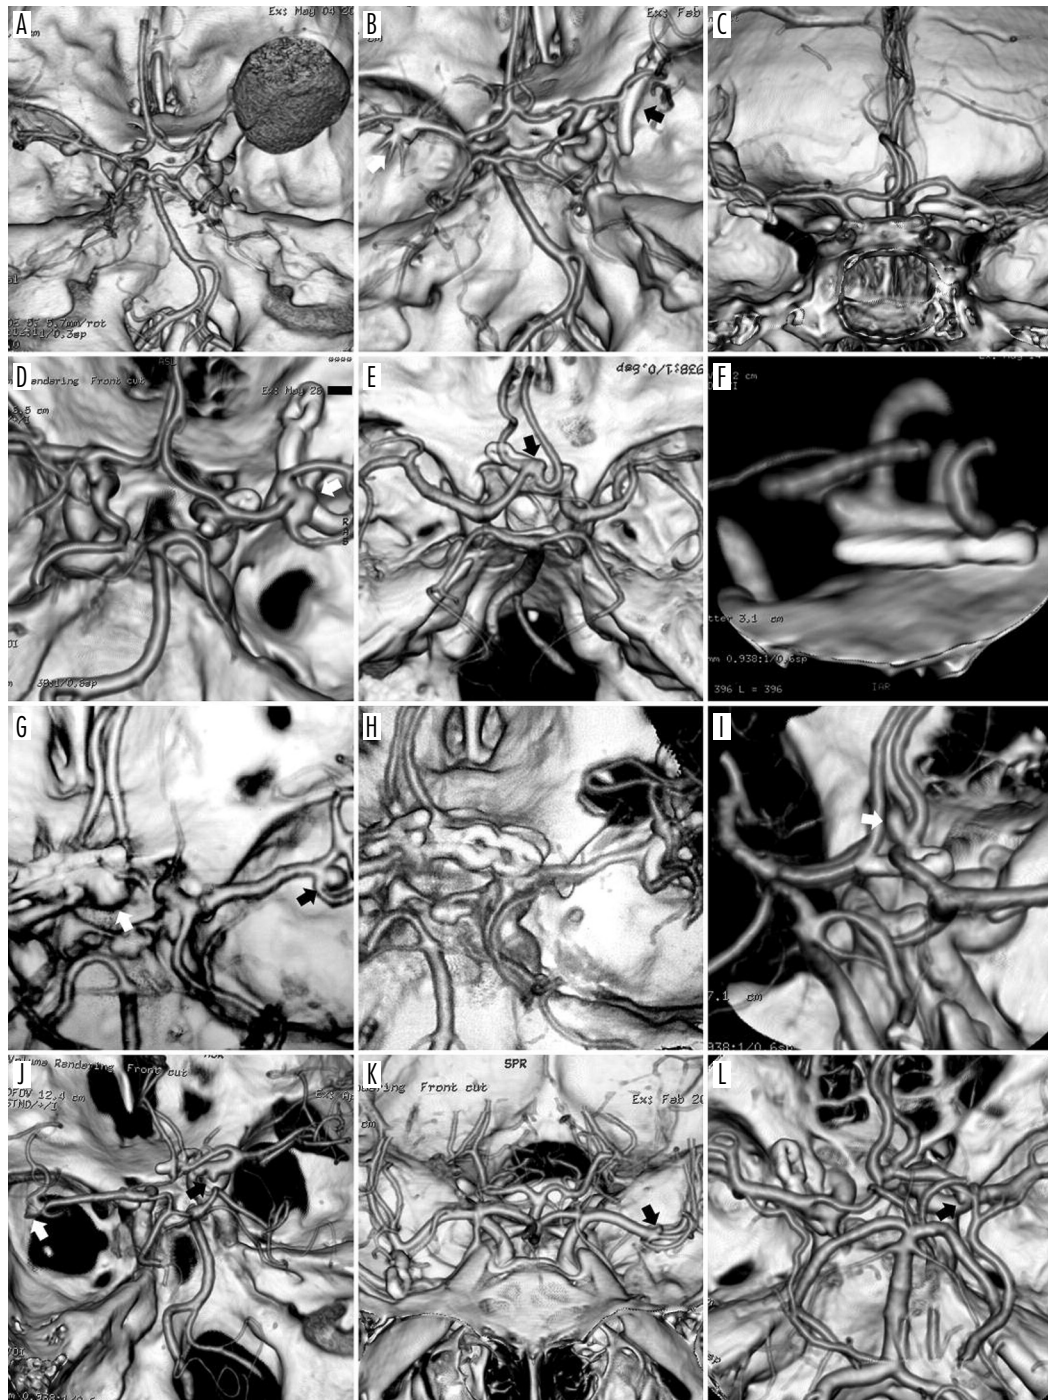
A) Giant, ruptured aneurysm of the right MCA and unruptured aneurysm of the left MCA. B) The same patient. Follow-up CTA showed no evidence of residual aneurysm 3 years after clipping (black arrow). Elective coiling of the unruptured aneurysm of contralateral MCA was performed. Assessment of coiling effectiveness is not possible in CTA because of artefacts (white arrow). C) Satisfactory follow-up CTA after right MCA and left ICA aneurysms clipping. D) Neck remnant after right MCA aneurysm clipping (white arrow) and new, small aneurysm of the left ICA just above PComA arising. CTA was performed 4 years after surgery. E) Neck remnant after AComA aneurysm clipping (black arrow). This is the first follow-up CTA, 6 years after surgery. F) The same aneurysm in magnification. Slow regrowth of the aneurysm in the future is suspected; thus the patient requires further observation. G) A case of rebleeding 11 years after clipping. The cause of re-rupture was AComA aneurysm regrowth at the previous clip site (white arrow). 'De novo' aneurysm of the right MCA (black arrow). H) Early follow-up CTA after re-operation (clipping of renewed AComA and 'de novo' MCA aneurysms). The quality of both reconstructions is poor, because of artefacts from older clips. I) Clip slippage (white arrow) and AComA aneurysm renewal. J-L) Small 'de novo' aneurysms (arrows) in distant locations from previously clipped aneurysms
